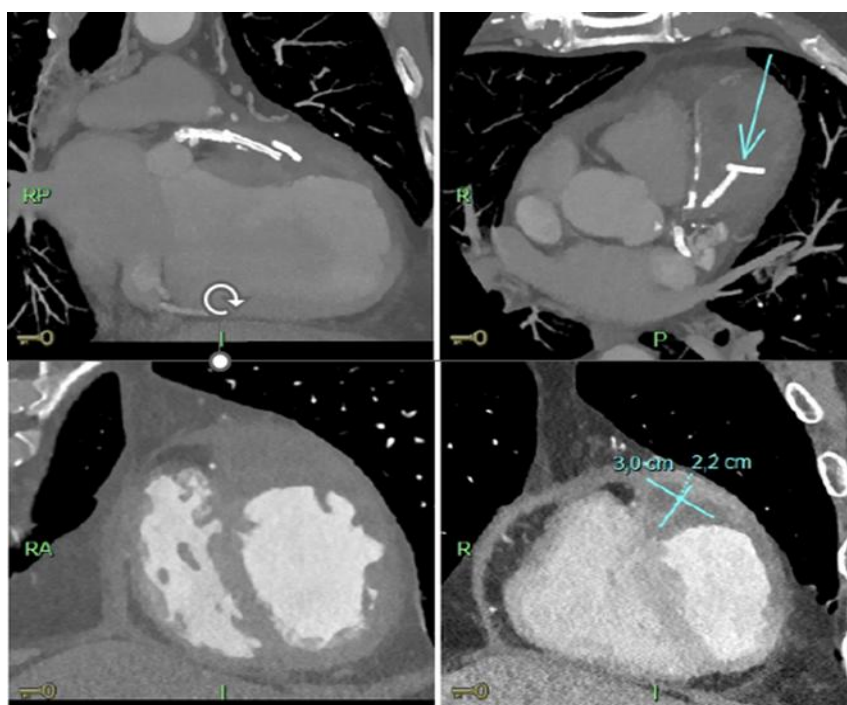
Heart-CT-scan, which shows left main thrombotic occlusion, epicardic hematoma and D1 stents seconded.
